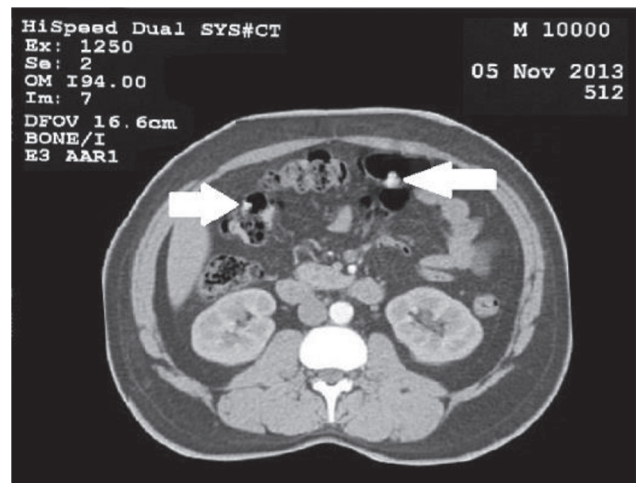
Axial CT scan abdomen with contrast showing multiple colonic polyps.
